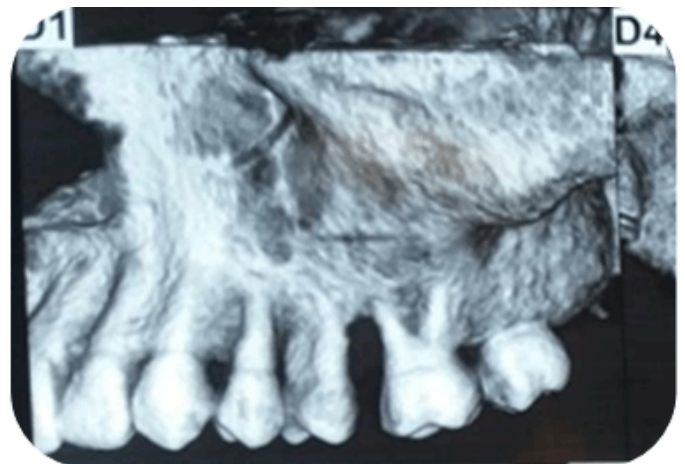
Cone beam computed tomography scan of maxilla showing bone loss around maxillary 2nd premolar and 1st molar.
